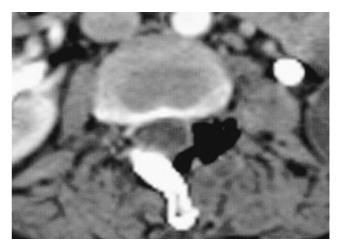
Postoperative CT image. The tumor mass was completely removed after total facetectomy of left L2-3 facet ioint.
